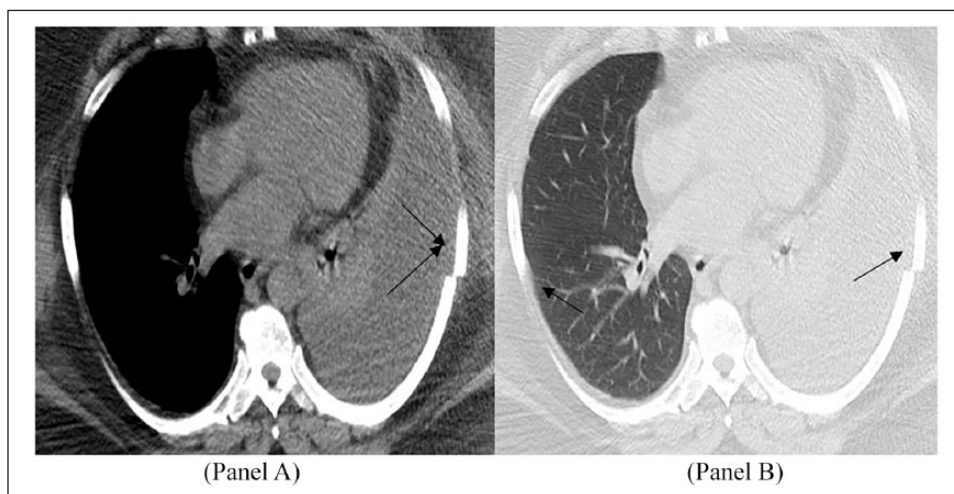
Contrast-enhanced computed tomography of the chest reveals a fracture of the seventh left rib in both the mediastinal (Panel A) and the lung window (Panel B) views (see arrows). In addition, a large pleural effusion is depicted in the left hemithorax.
